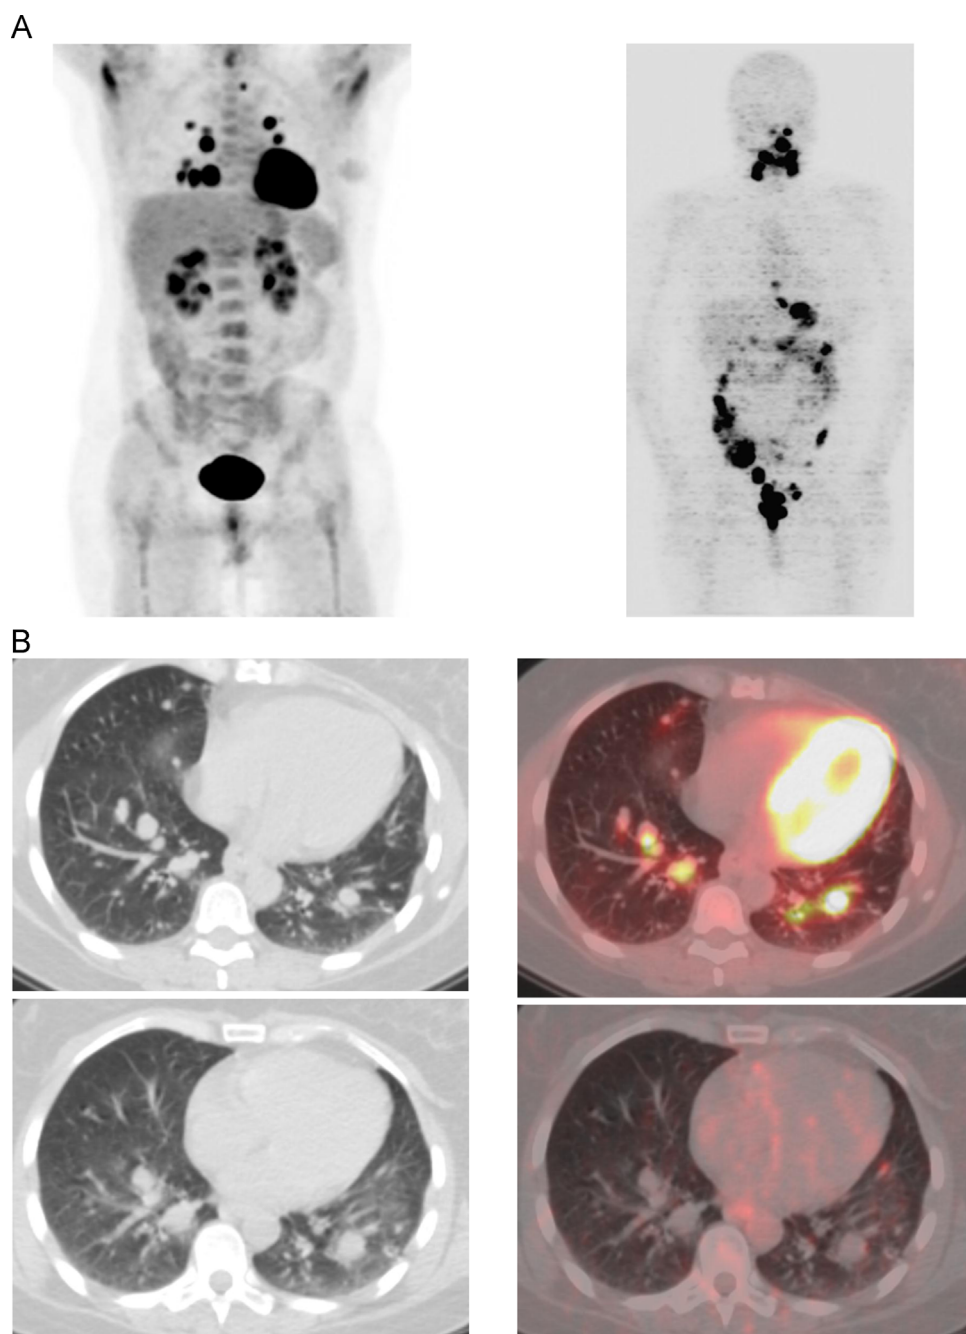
(A) Flip-flop phenomenon showing multiple FDG-avid lung metastases, which are not iodine avid on I-124 PET scan. (B) Flip-flop phenomenon showing multiple FDG-avid lung metastases, which are not iodine avid. Top row transaxial images are FDG-PET and bottom row transaxial images are I-124 PET.
